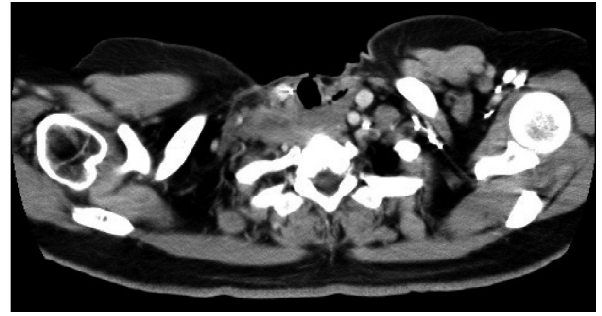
Computed tomographic scan after 16 months of chemotherapy showing excellent tumour shrinkage and removal of the tracheostomy tube
